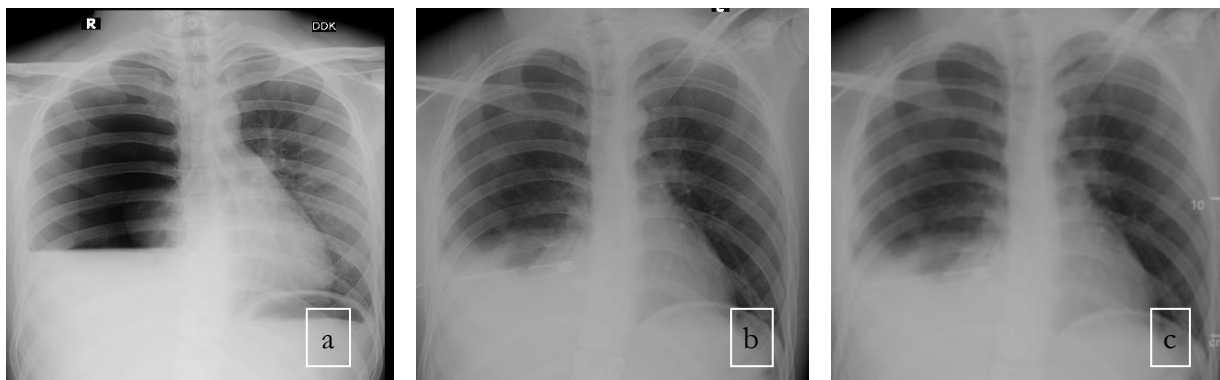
Follow-up Chest X-ray; a) when entered the emergency room, b) after WSD installation; and c) after six days of treatment
